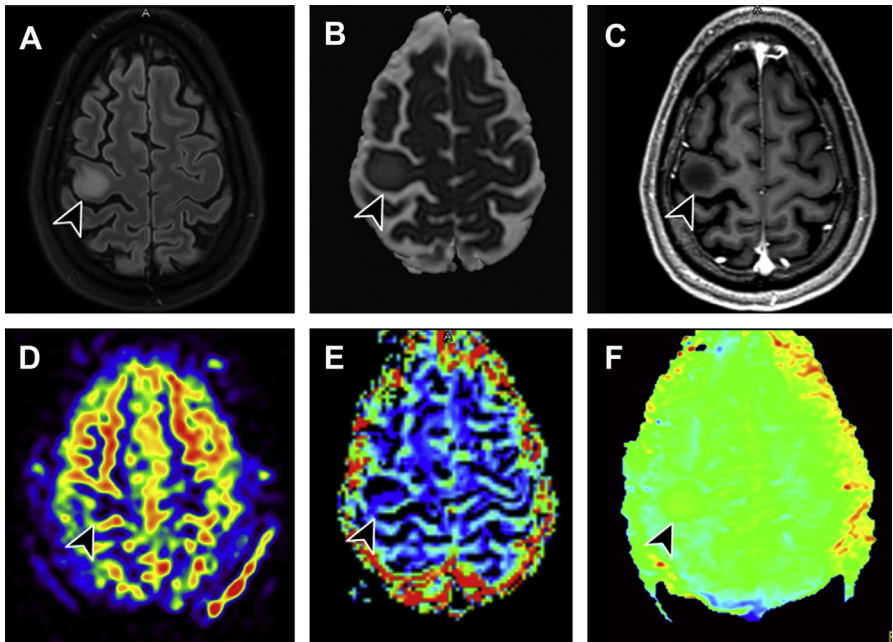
Multiparametric imaging of a low-grade glioma with brain perfusion and amide proton transfer (APT) imaging. The infiltrative tumor is located in the right precentral gyrus (black arrowhead), exhibiting hyperintense signal on FLAIR (A), increased diffusion on ADC (B), and no abnormal contrast enhancement (C). The 3D pCASL-derived CBF map (D) and the DSC-derived rCBV map (E) show no increased perfusion compared with the normal parenchyma. Subtle signal increase is seen on the APT (F, arrowhead). The physiologic findings are consistent with a low-grade tumor and are in accordance with the structural scans.
